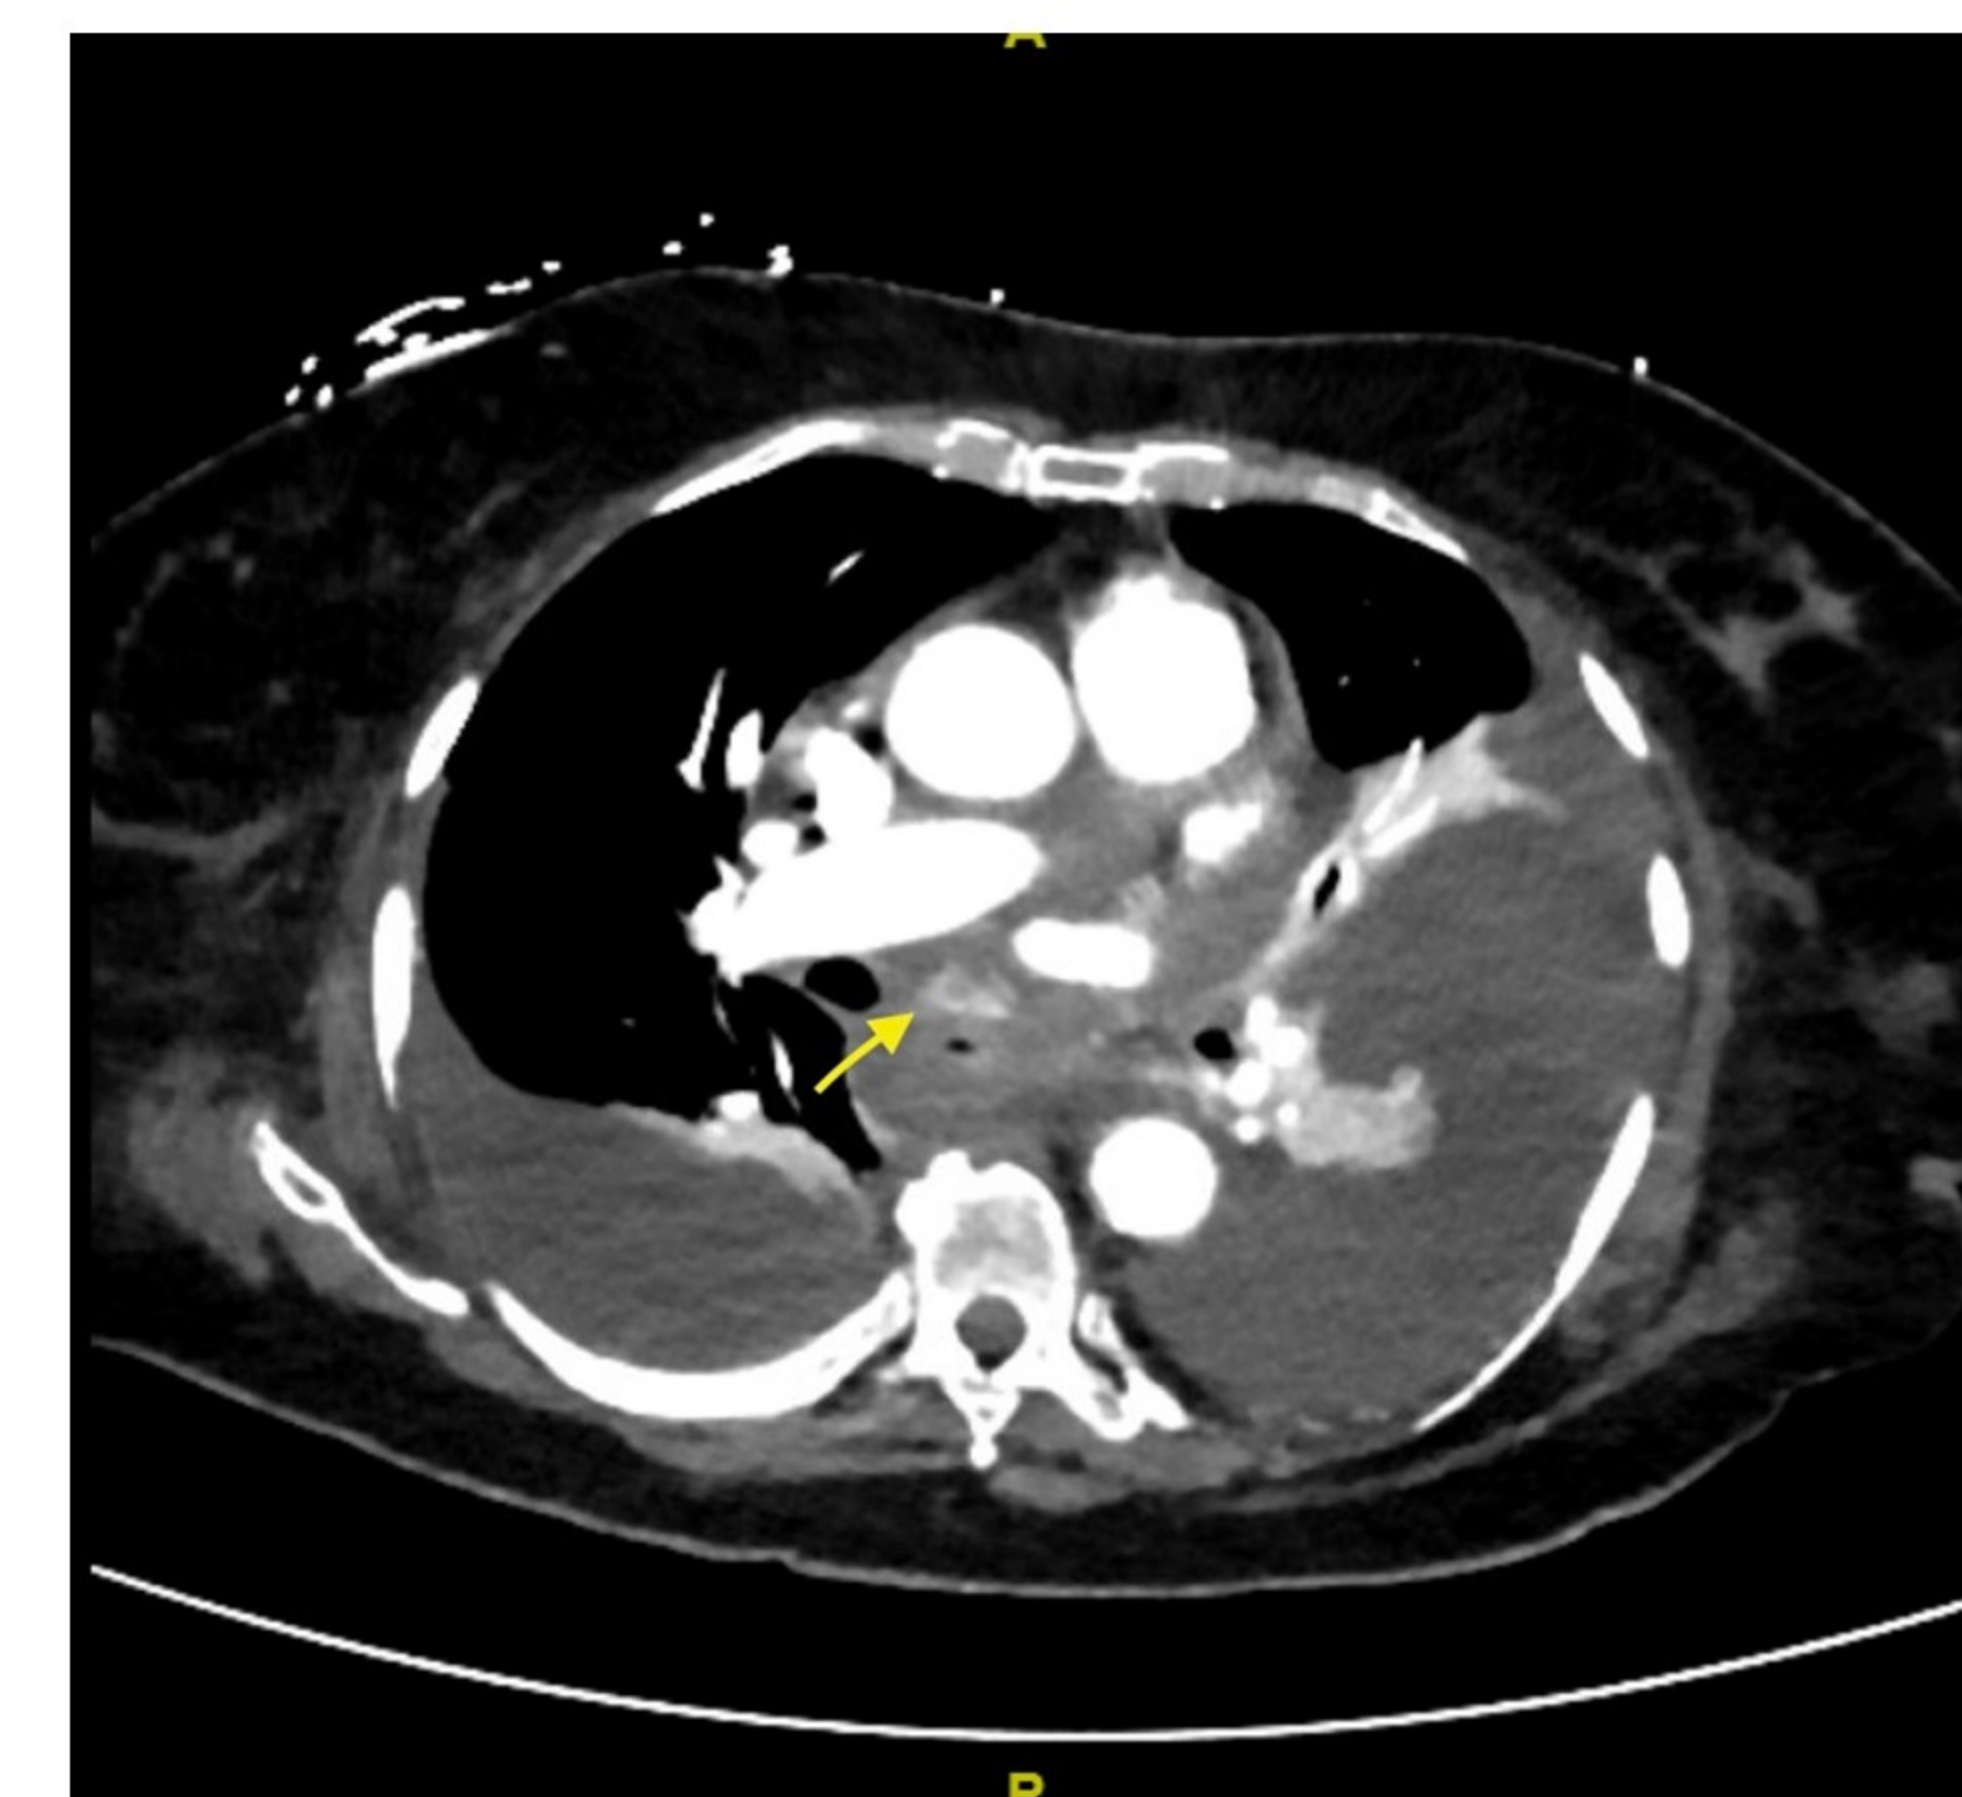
CT Angiogram Chest with esophageal artery contrast blush.
